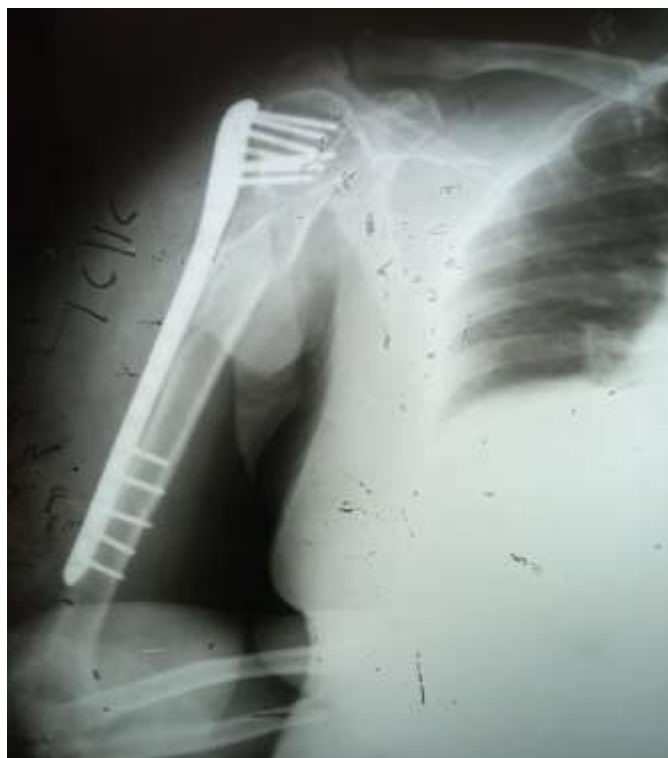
one month post operative X-Ray
